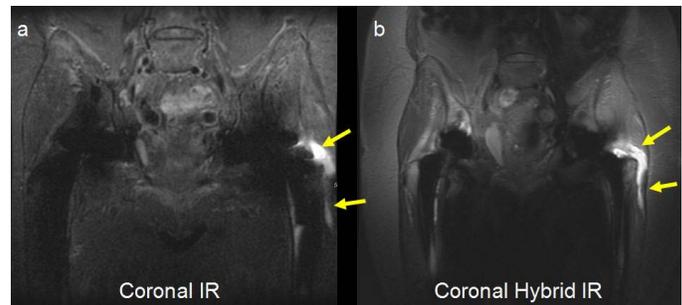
(a, b) Coronal MR images in a 74 year old woman with bilateral total hip arthroplasties presenting with left hip pain. A large fluid collection is seen in the left trochanteric bursa in both (arrows) but significantly less metallic artifact is seen on Hybrid.
